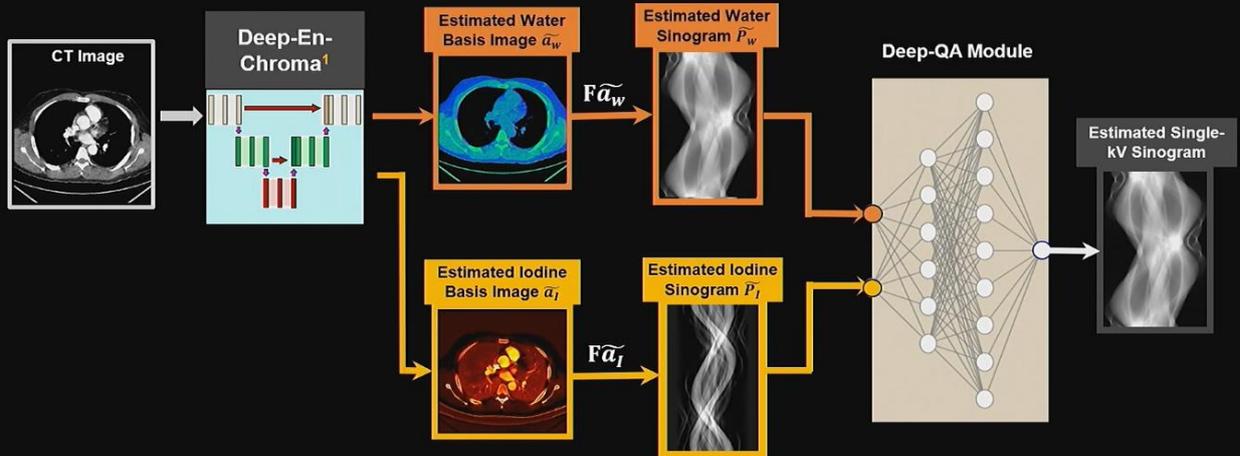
圖十八、使用 Dual-Energy CT 建立品質控制的深度學習網路 [12]
